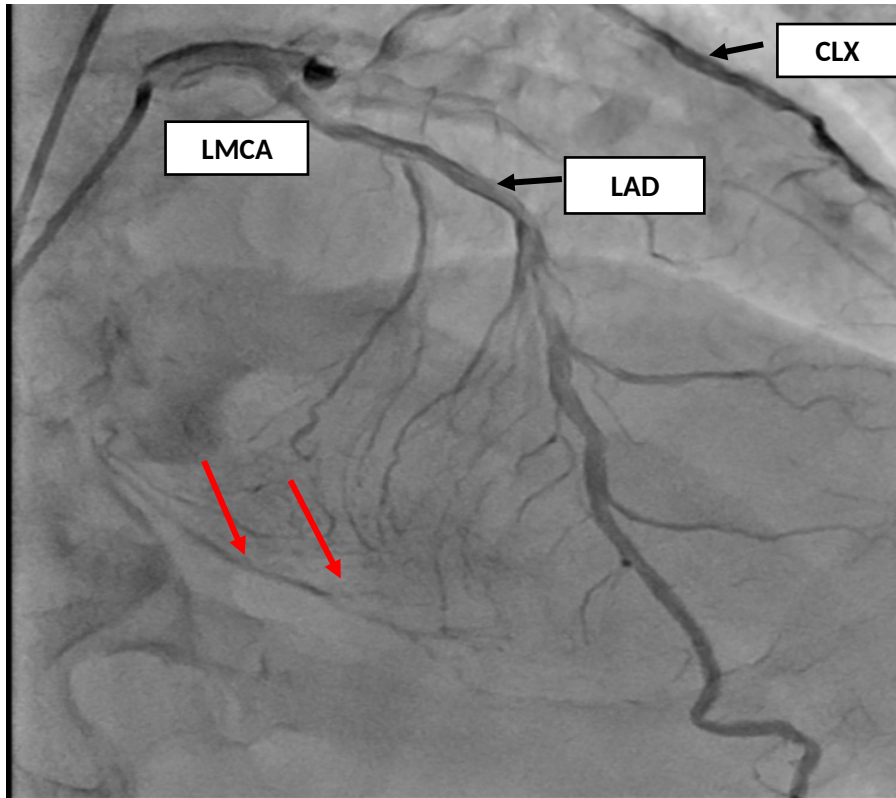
Coronary angiogram with injection of radiographic contrast into Left main coronary Artery (LMCA).
